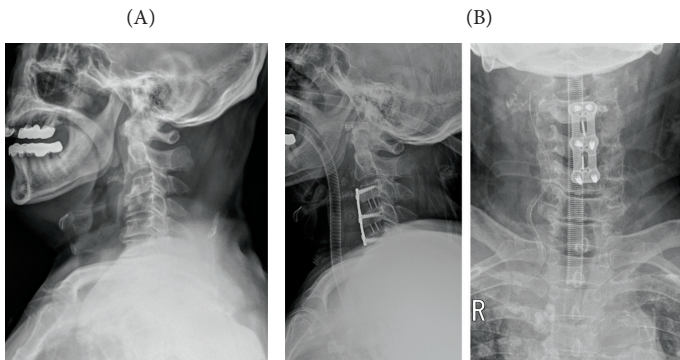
Patient's cervical spine X-ray (A) lateral view on August 18, 2019 (B) anteroposterior, lateral view after surgery (August 19, 2019).
